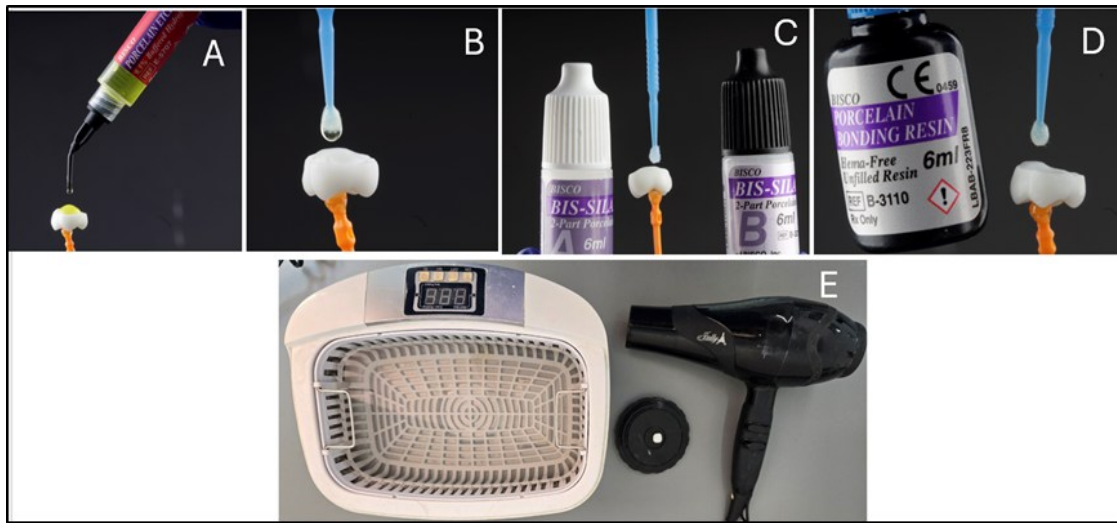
Steps involved in lithium disilicate conditioning. (A) Hydrofluoric acid 9.5% (Bisco, USA); (B) washing and drying; (C) two-bottle silane system (Bisco, USA); (D) non-filled ceramic bonding agent (Bisco, USA); (E) Ultrasonic water bath, air dryer, and veneer-me set used in the conditioning of the intaglio surface of the overlay
